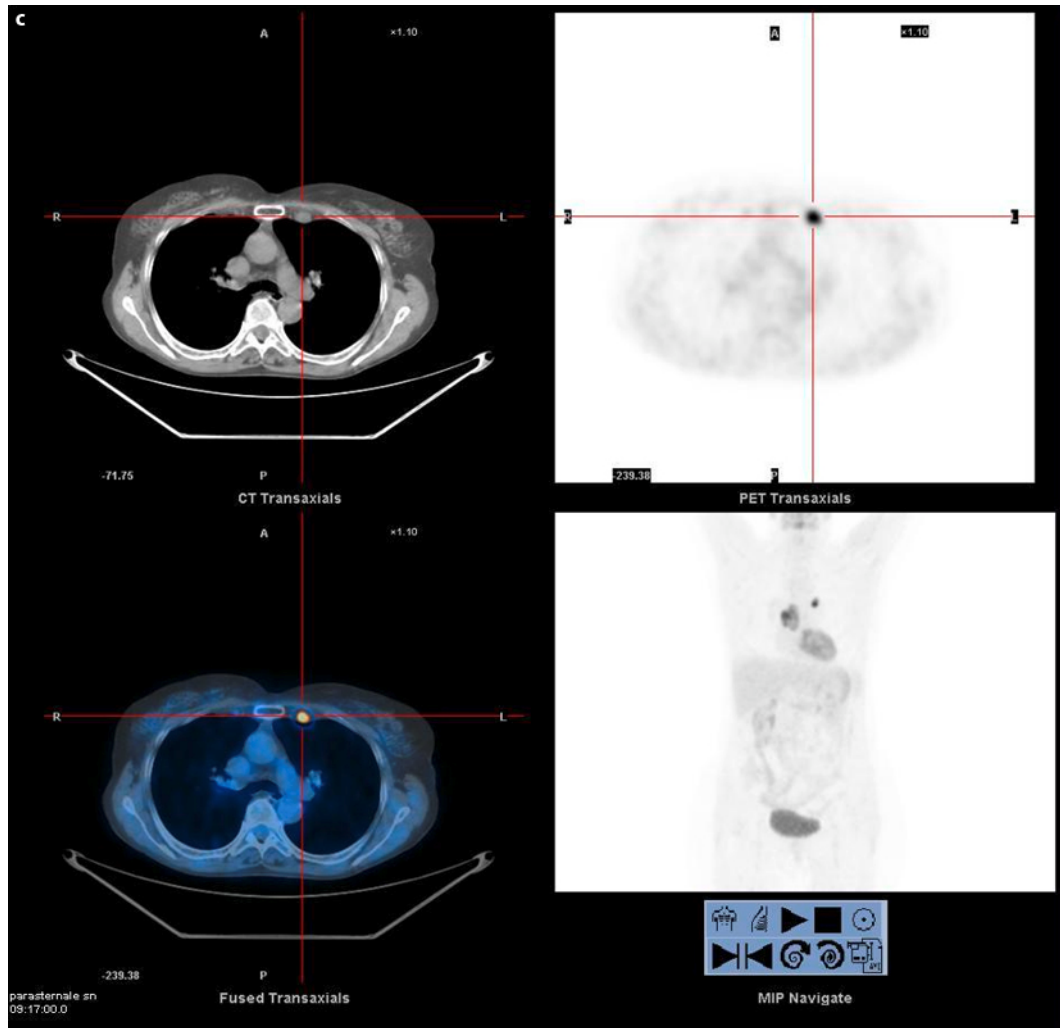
Case 1. FDG-PET/CT scan shows increased uptakes in bilateral internal mammary lymph nodes (a and b) with involvement of right side of the sternum (c).
